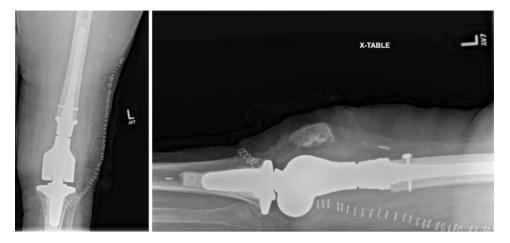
Anteroposterior and lateral radiograph of the left knee after operation.
